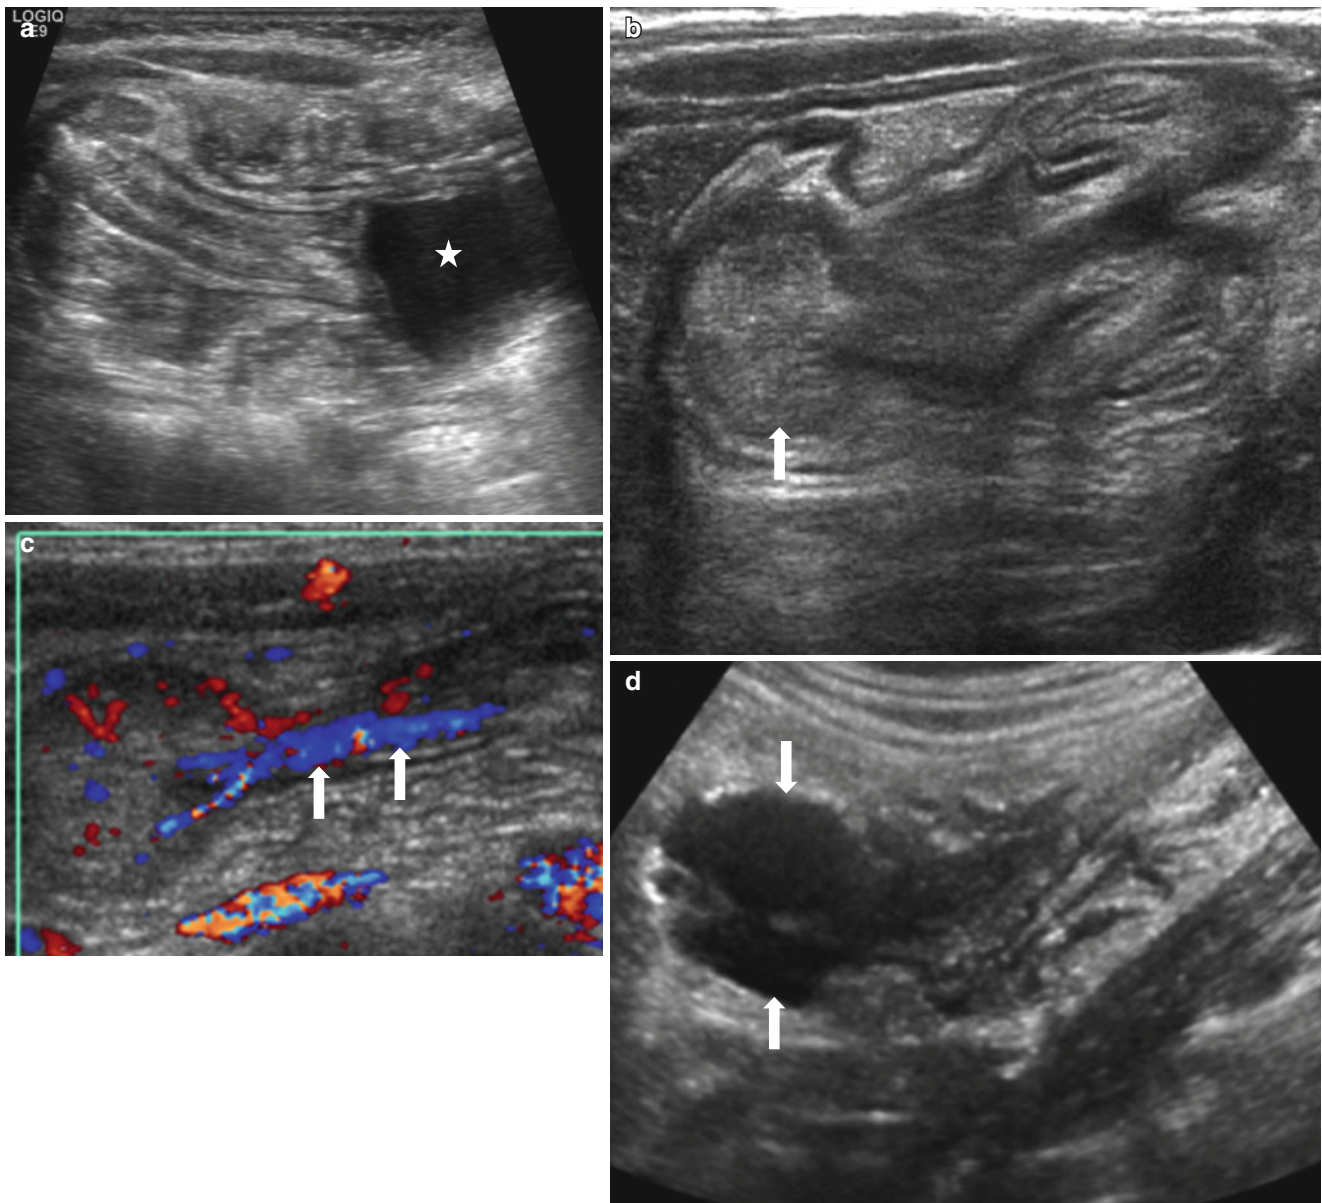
Three different cases of intussusception with pathologic lead points. (a) US in a 7-month-old girl presented with cyclic irritability shows an intussusception (*arrows*) in a longitudinal axis. A cystic lesion (*asterisk*) with inner echogenic and outer hypoechoic wall is present as a lead point, which turned out to be a duplication cyst. (b, c) US images in a 4-year-old girl who had multiple episodes of intussusception demonstrate a polypoid lesion within the bowel leading to a short segmental ileocolic intussusception. On color Doppler image (c), prominent vascular flow is noted in the polyp and the stalk (*arrows*).
